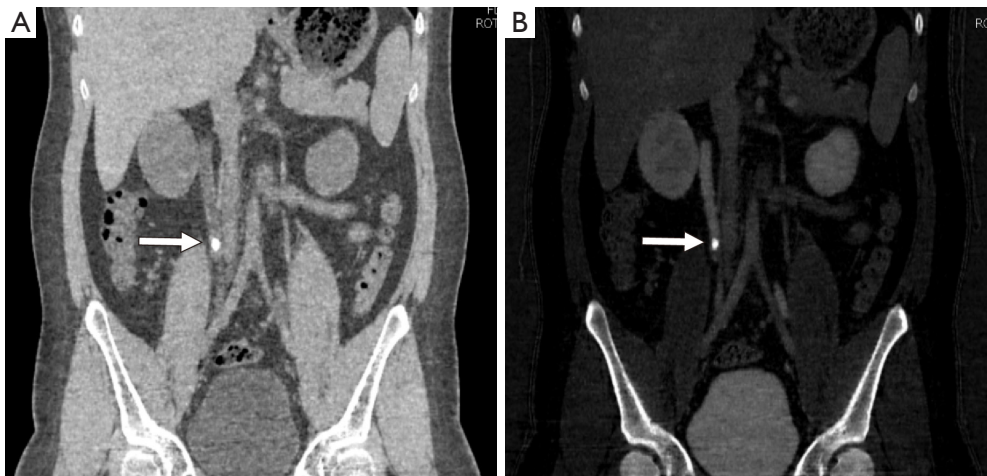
Material separation of DECT. The coronal images were water-based images (virtual non-contrast CT) (A) and iodine-based images (B). These images showed that calculi presented as high-density in the middle urinary tract (white arrows). DECT, dual-energy computed tomography.
